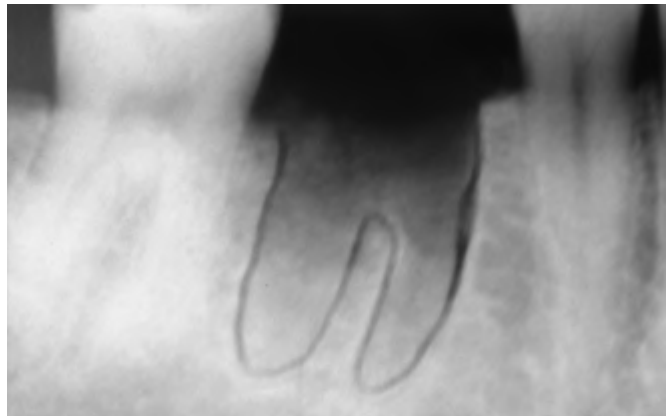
Radiograph taken of the extraction socket immediately post extraction. The outline of the roots was drawn by the periodontist.
